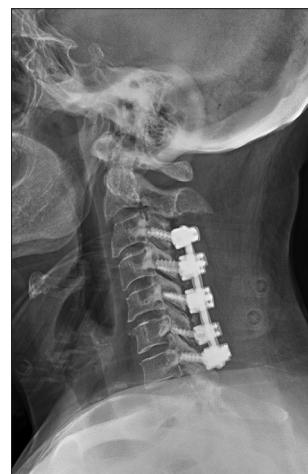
Lateral plain radiograph following C3-7 laminectomy and fusion demonstrating placement and trajectory of lateral mass screws
